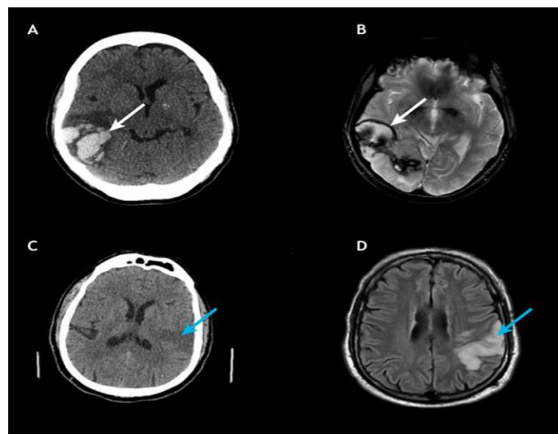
CT scans against MRI scans for stroke detection. (A, B) A hemorrhage may be plainly observed in a patient's CT scan (A; white arrow), although it is less visible in an MRI scan (B; white arrow). (C, D) An ischemic infarct is just faintly visible in a C. [9].
